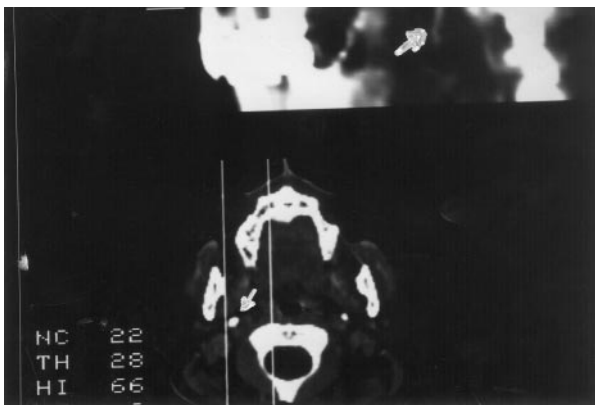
CT scan of head and neck, demonstrating length, angulation and anatomical relationships of the styloid process.
